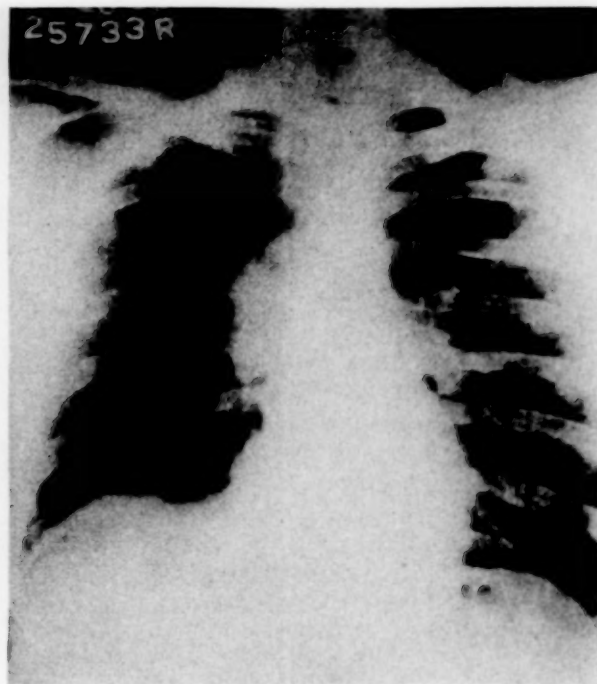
X-ray taken one week after completion of radiation therapy, Case III.
